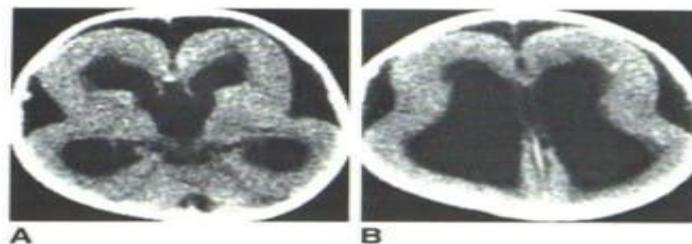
MDS with Type I lissencephaly. A CT scan after a month. B: A higher cut.
